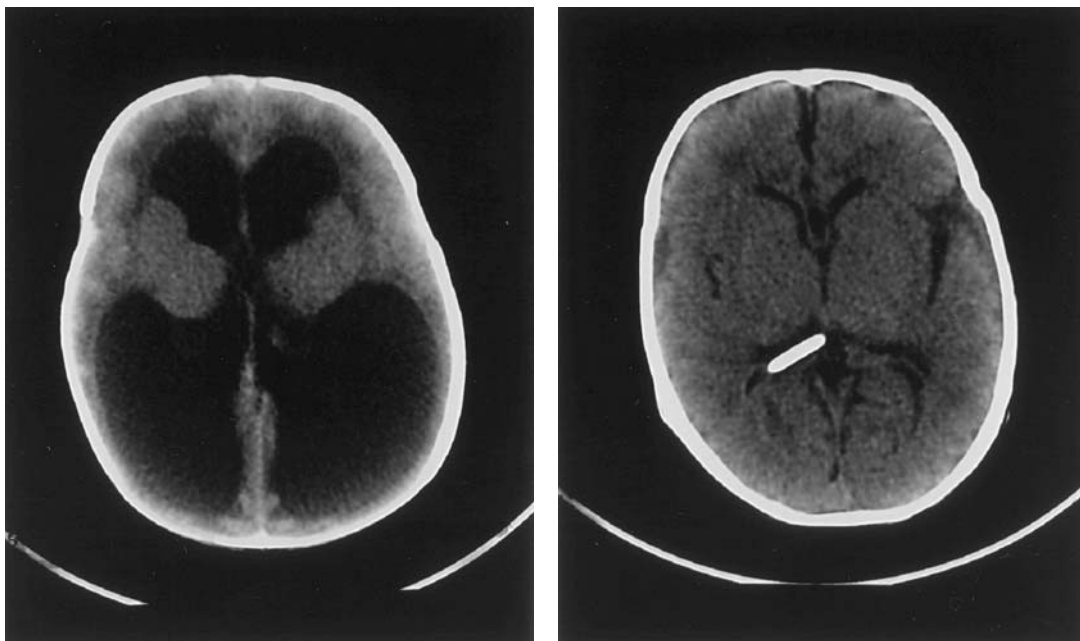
CT scan appearances before (left) and 6 weeks after (right) the insertion of a VP shunt.
